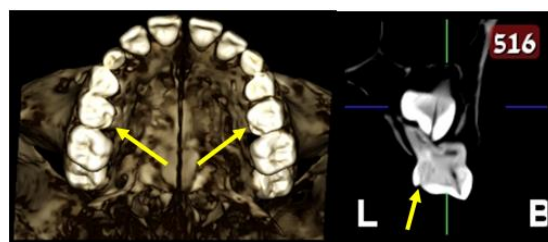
CT view of the occlusal surface of the dentition and slice of tooth #65.
